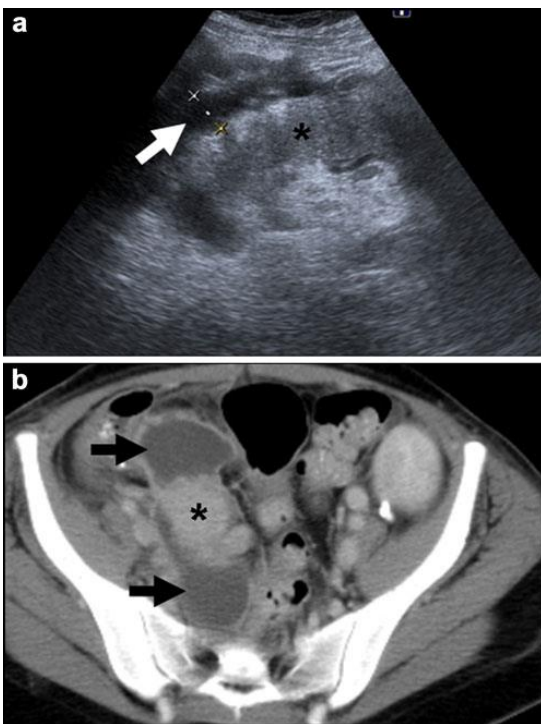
A 30-year-old woman 5 weeks after SPK transplantation with an infected peri-pancreatic pseudocyst. Sagittal ultrasound of the right lower quadrant (a) demonstrates a peri-pancreatic fluid collection (white arrow). Axial contrast-enhanced MDCT (b) shows homogeneous contrast enhancement of the pancreatic graft (asterisk) surrounded by a thin, contrast-enhanced wall fluid collection (black arrows). Image-guided percutaneous drainage confirmed superimposed infection of the pseudocyst
